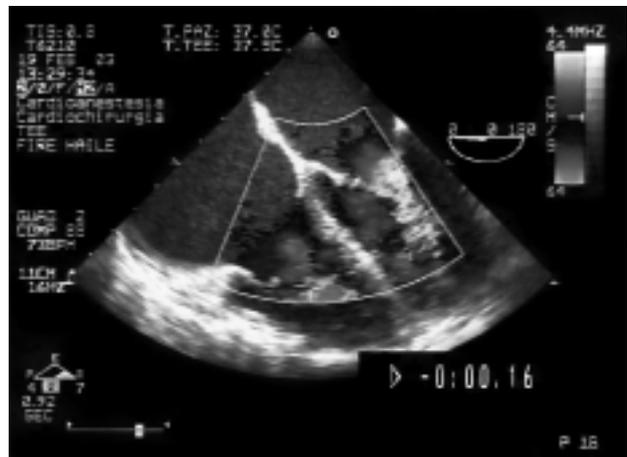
Transesophageal echocardiography: postoperative image of the mitral and tricuspid valves confirming no residual regurgitation.
